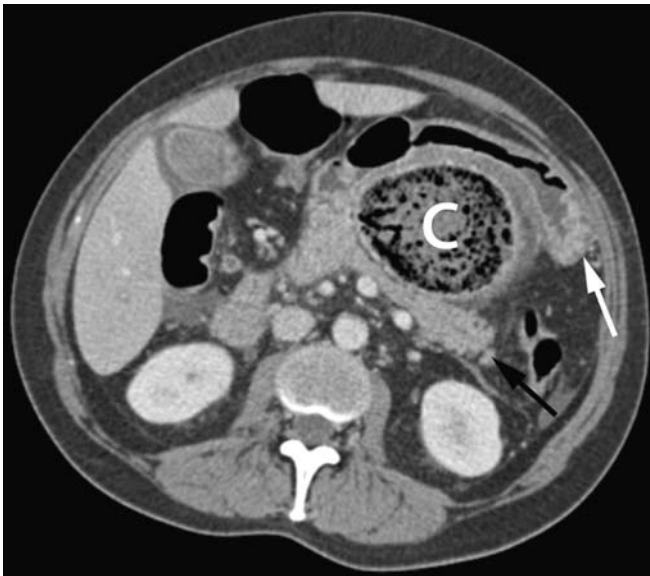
Axial contrast-enhanced CT image showing the caecum (C) herniated into the lesser sac between the stomach (white arrow) and pancreas (black arrow)
